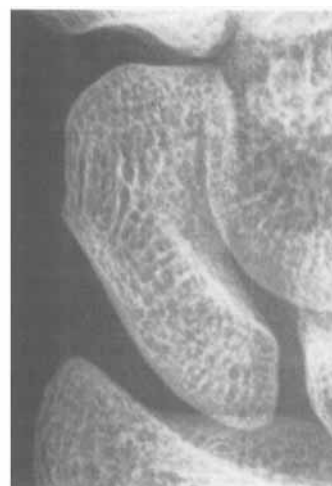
Macroradiographs 4 days after trauma show no fracture of the scaphoid in a 17-year-old girl. The patient still complained about pain in the anatomical snuff-box 10 and 24 days after trauma. 42 days after trauma, radiographs showed a line of sclerosis, indicating a remodeling process after a scaphoid fracture.
